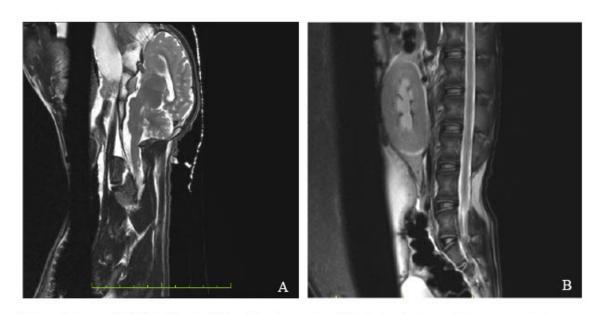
3-month MRI of brain (A) and lumbar spine (B) of a lamb that underwent surgical intervention with application of the PMSC-ECM product.
